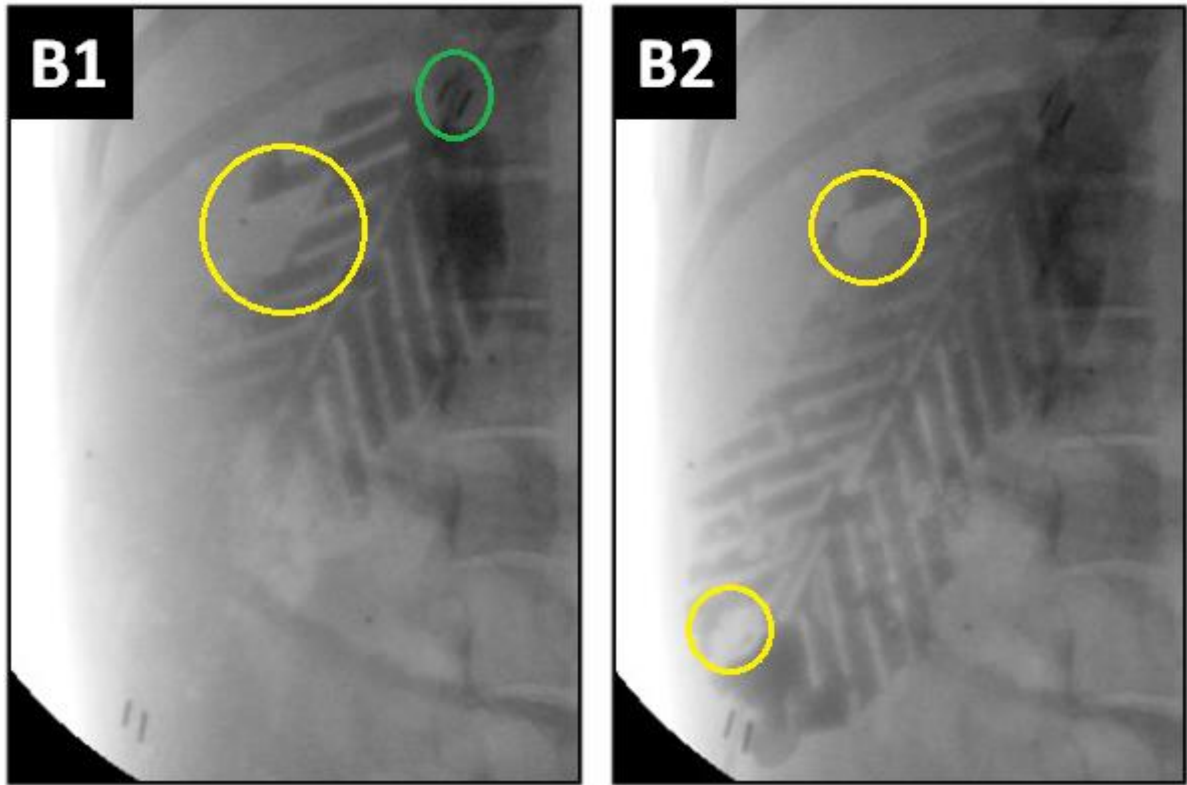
CT scan images of Shell B taken while filling with RGF1, where A1 was taken before A2. (B1) – Shows the filling port outlined in green, and a section of the shell that has not filled outlined in yellow. (B2) – Shows the gel spreading throughout the shell, with multiple air bubbles and the largest air bubbles outlined in yellow.
